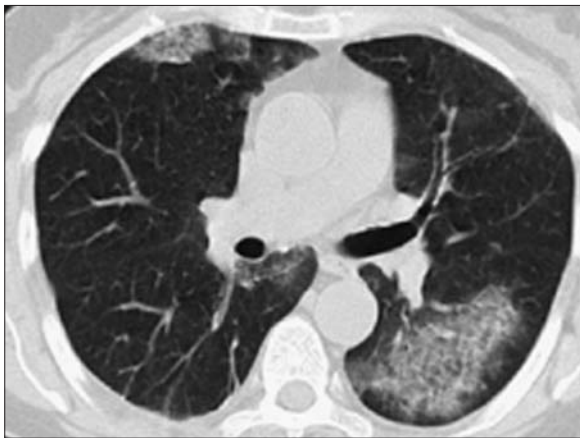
CT scan obtained after tapering the steroid dose shows new ground glass densities in both lungs (right middle lobe and superior segment of lower lobe of left lung).
